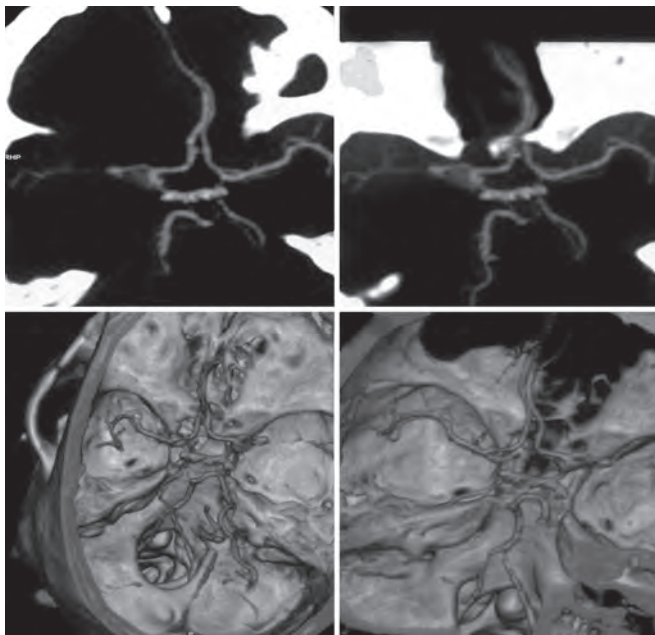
CTA showing Rt. M1 aneurysm
